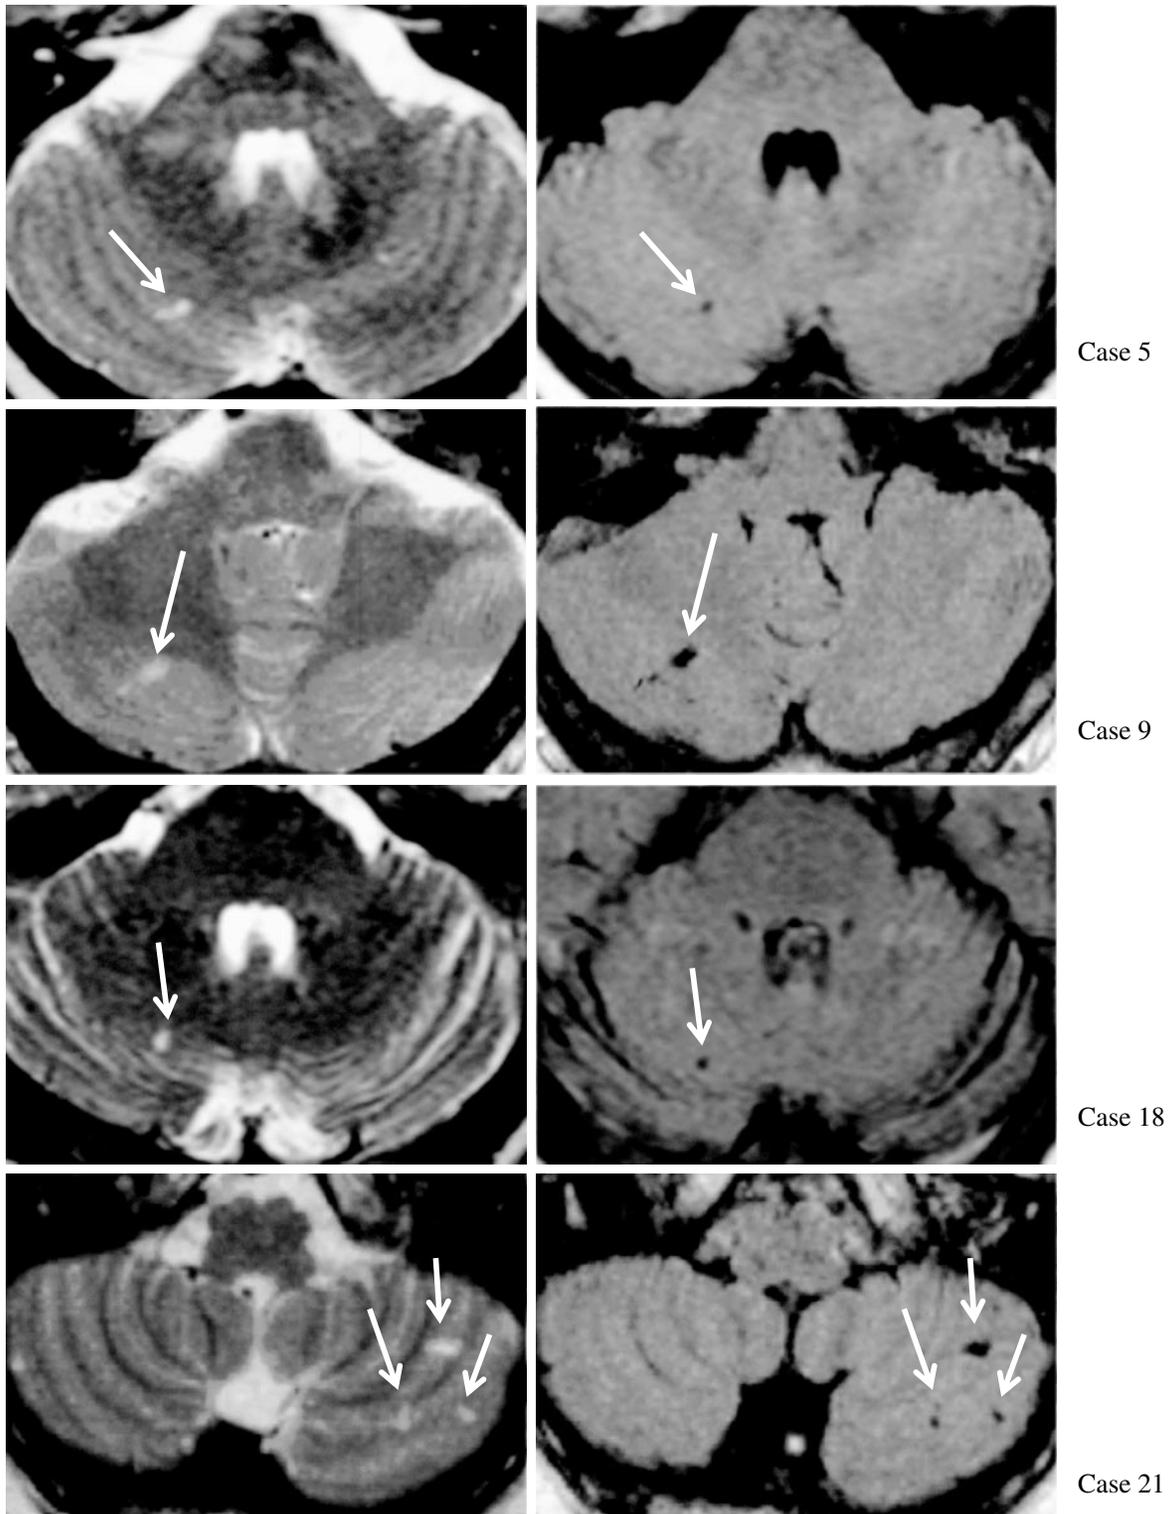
Cerebellar infarct-like lesions: the CAMERA study. Corresponding T2-weighted (left) and fluid-attenuated inversion-recovery images (right) showing (multiple) cerebellar infarct-like lesions (arrows) in four representative cases (numbers refer to case numbers in Table 2).
